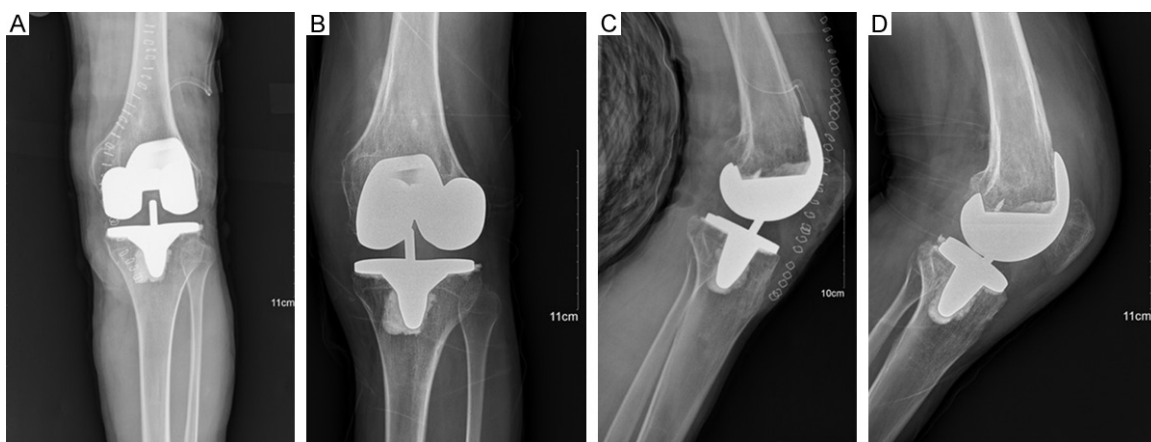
X-ray appearance of patient during operation and 6 months follow-up after operation. A and C. Posteroanterior and lateral X-ray of left knee during operation; B and D. Posteroanterior and lateral X-ray of left knee 6 months after operation.
